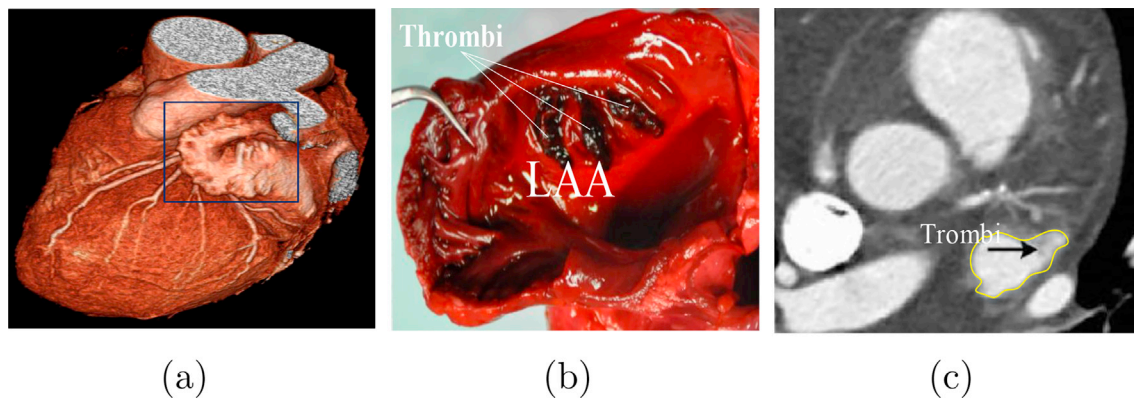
The LAA, LAA thrombi and an axial CT slice with the LAA. (a) Volume rendering of a heart with the LAA marked by a rectangle, (b) LAA thrombi, (c) An axial CT slice with the LAA marked by a yellow border. (For interpretation of the references to color in this figure legend, the reader is referred to the Web version of this article.)
